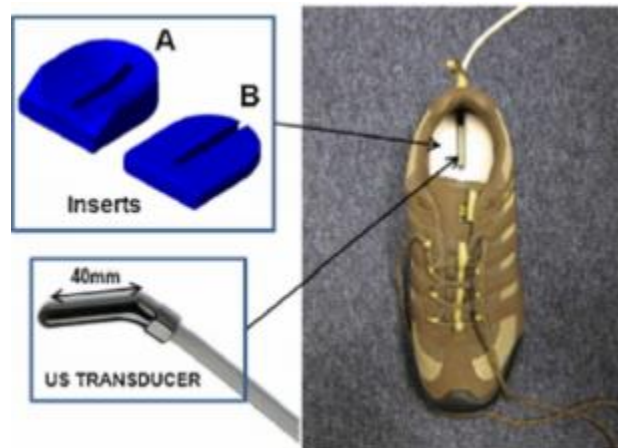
Set up of shoe for Telfer et al.’s study with the ultrasound probe positioned under the heel [33].
